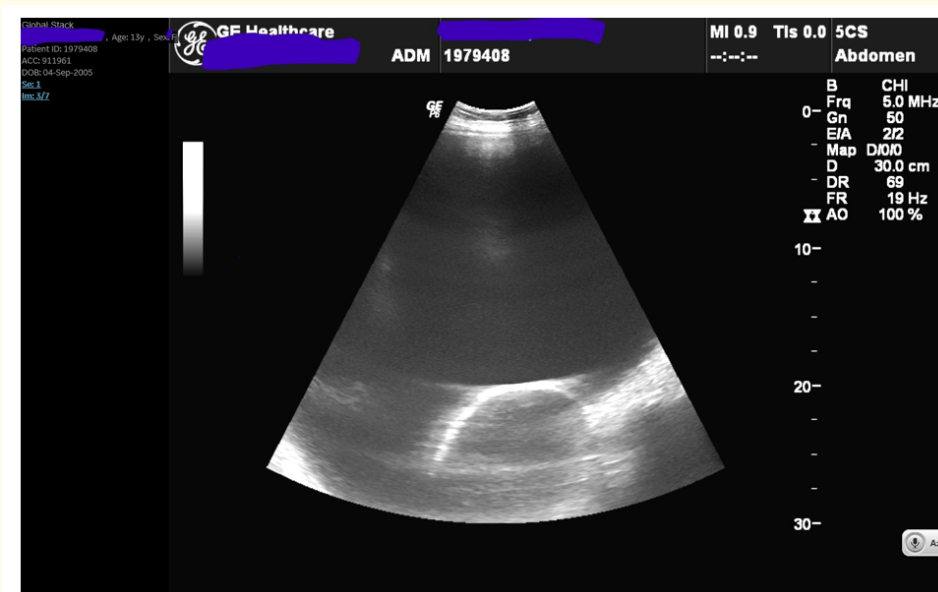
Ultrasound abdomen.
